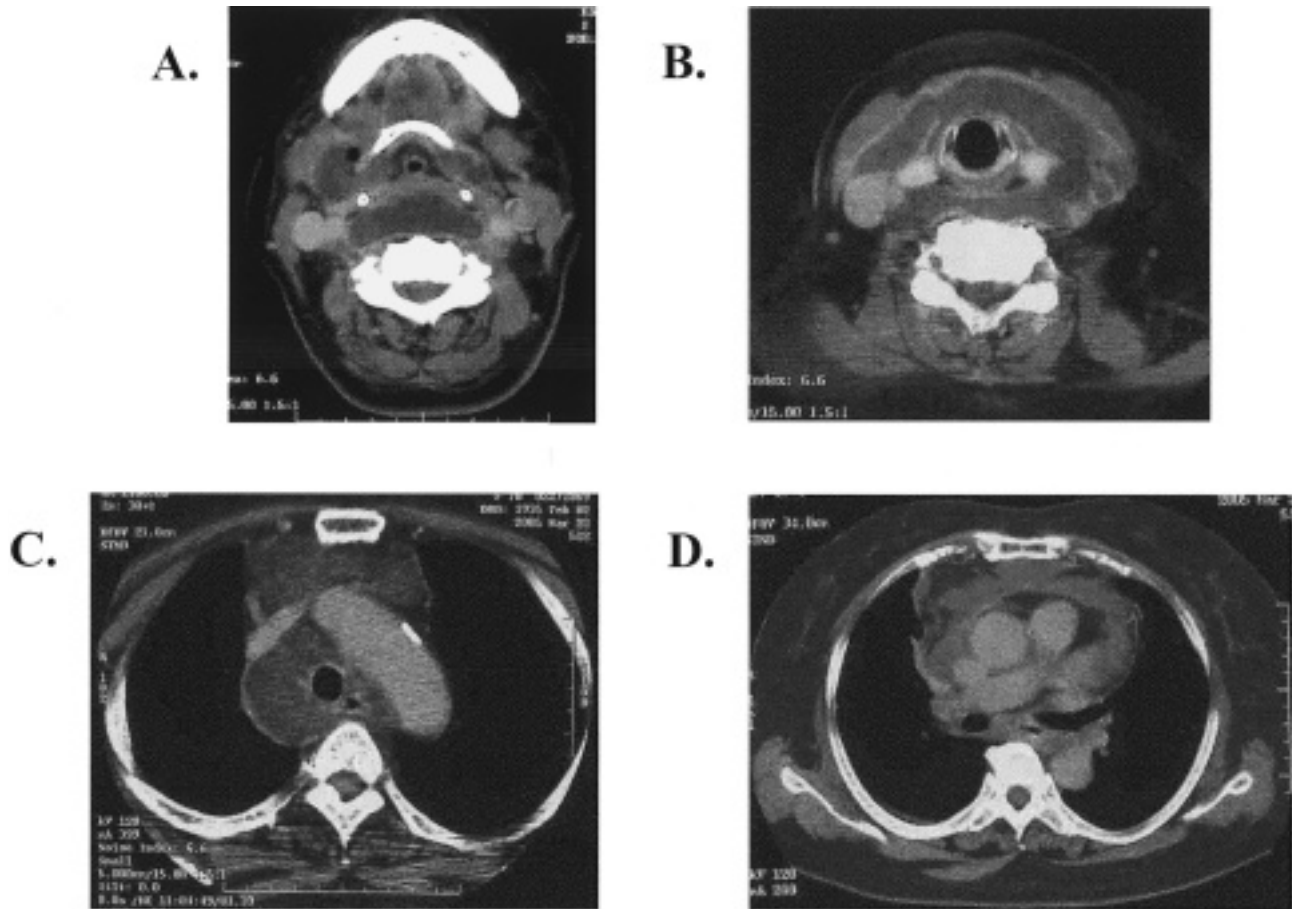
CT scan from neck to chest before operation. Retropharyngeal abscess (A), deep neck abscess (B), and anterior mediastinum (C) were confirmed, however, abscess did not extend posterior mediastinum and below the tracheal bifurcation (D).
